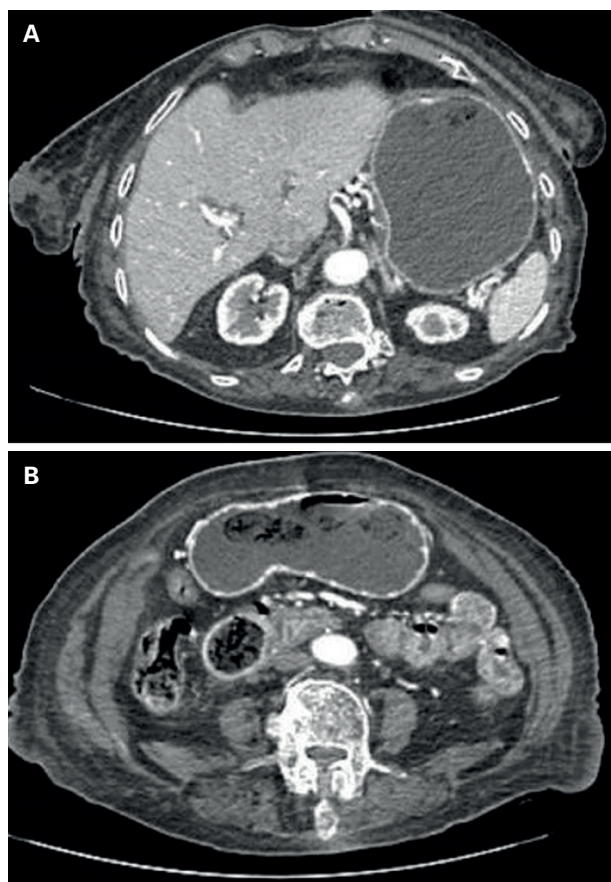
Abdominal computed tomography. A. Gastric distension. B. Ovaloid intraluminal foreign body with heterogenous density in the second portion of the duodenum.
